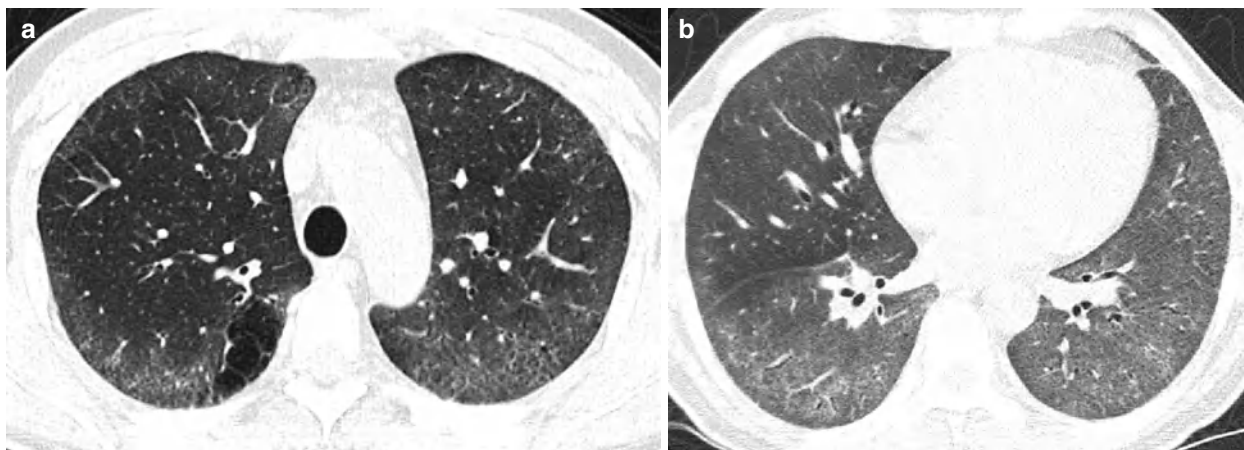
Interstitial fibrosis of nonspecific interstitial pneumonia pattern in a 49-year-old man with Sjögren's syndrome. (a, b) Lung window of CT scans (2.5-mm section thickness) obtained at levels of aortic arch (a) and inferior pulmonary veins (b), respectively, show patchy
